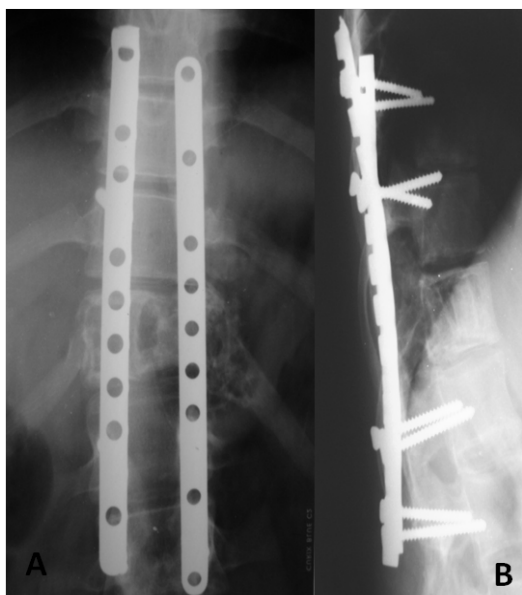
Anteroposterior (A) and Lateral (B) thoracic radiographs obtained 3 year after operation showing fusion of the arthrodesis
